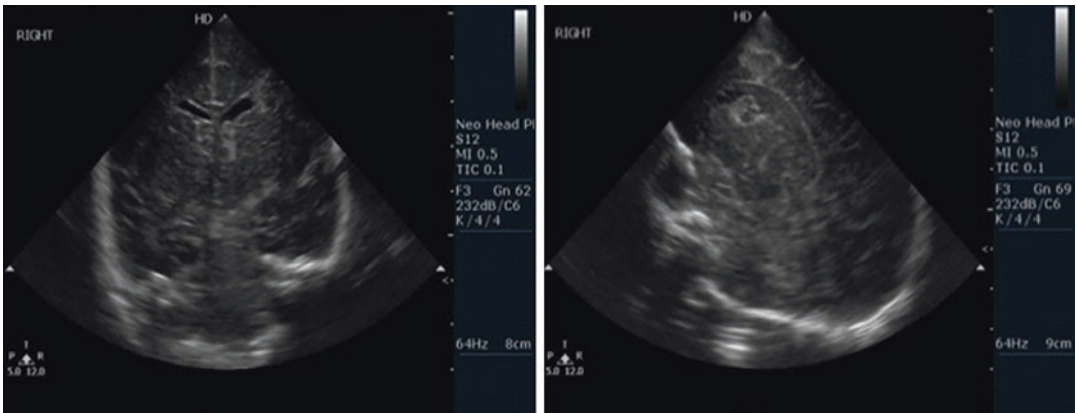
Grade I Germinal Matrix Haemorrhage. Intracranial ultrasound, coronal (left) and sagittal (right) views, showing high echogenicity haemorrhagic material at the caudothalamic groove
